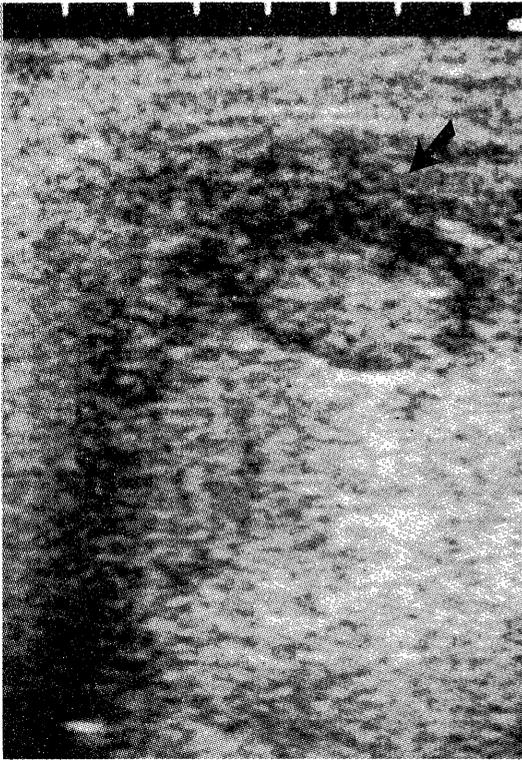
Emergency ultrasonography in Case 6 showing 4.7×3.5 cm hypoechoic lesion with an abrupt of peripheral rim (arrow) which suggested ruptured HCC.
